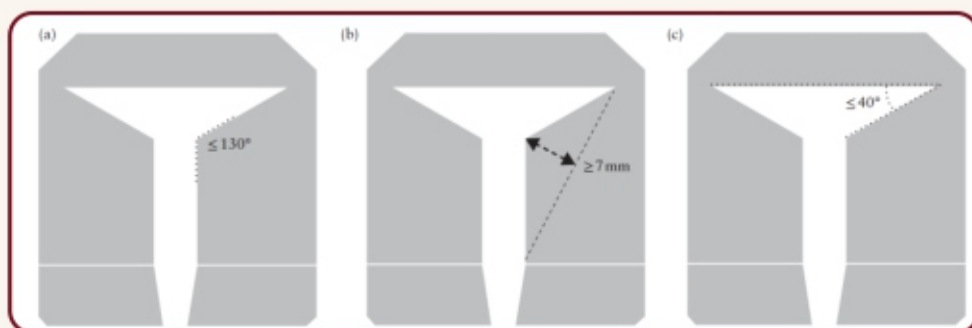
Copied from Ultrasound Obstet and Gynecol: CUME criteria for diagnosis of T shaped Uterus T-shaped uterus as defined by CUME (Congenital uterine malformation by experts), according to presence of three criteria beyond particular cut-offs: (a) lateral indentation angle $\le 130^\circ$, (b) lateral indentation depth $\ge 7\text{mm}$ and (c) T-angle $\le 40^\circ$. Presence of two of these three criteria is defined as borderline T-shaped uterus, whereas lack or presence of only one of these criteria is defined as normal uterus with respect to lateral uterine morphology. This definition is supported by reliability and diagnostic accuracy testing of measurements, and by post-test probability $>90\%$ for target population, considering diagnosis made most often by experts as reference (i.e. CUME).
